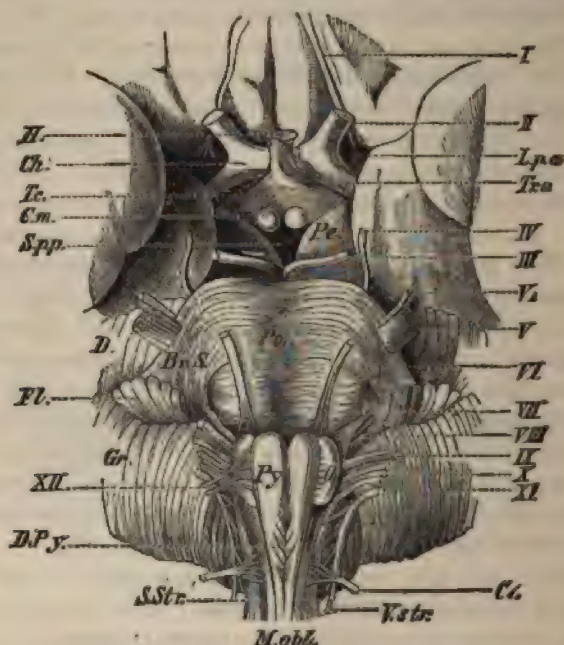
BASAL ASPECT OF THE CEREBRAL AXIS
